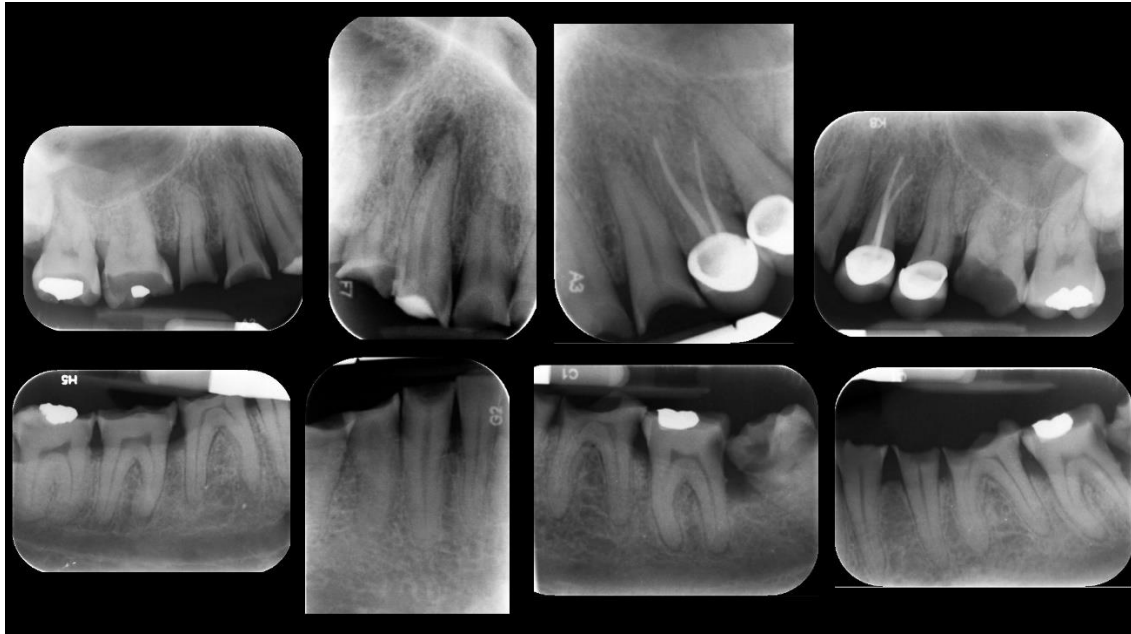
Full mouth periapical radiographs (pre-operative)
